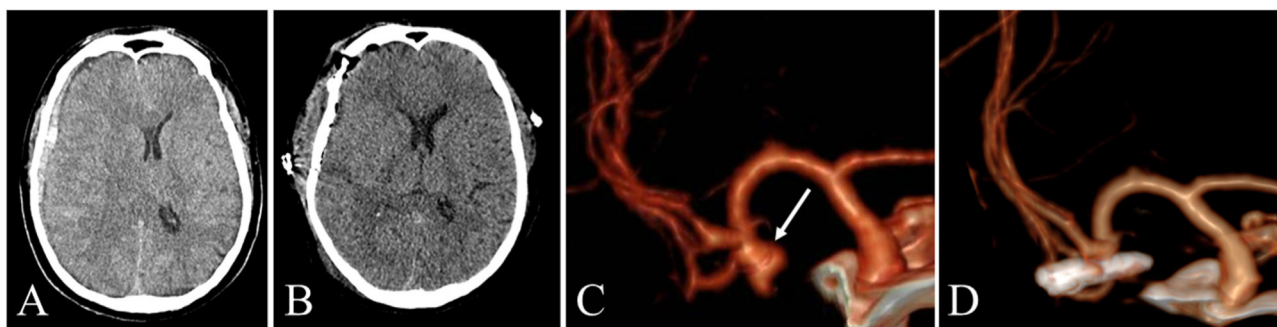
Patient 1. Image A: preop noncontrast CT, it shows a disproportionate mass effect to the hematoma size. Image B: postop noncontrast CT (24 h). Image C: preop CT angiography (CTA), it shows an anterior and lateral projection in a 3D reconstruction. The white arrow points the MCA aneurysm (M1). It is demonstrated the MCA anterior concavity and the aneurysm anterior projection. Image D: postop CTA, it shows an anterior and lateral projection in a 3D reconstruction. It is demonstrated the adequate aneurysm clipping.
